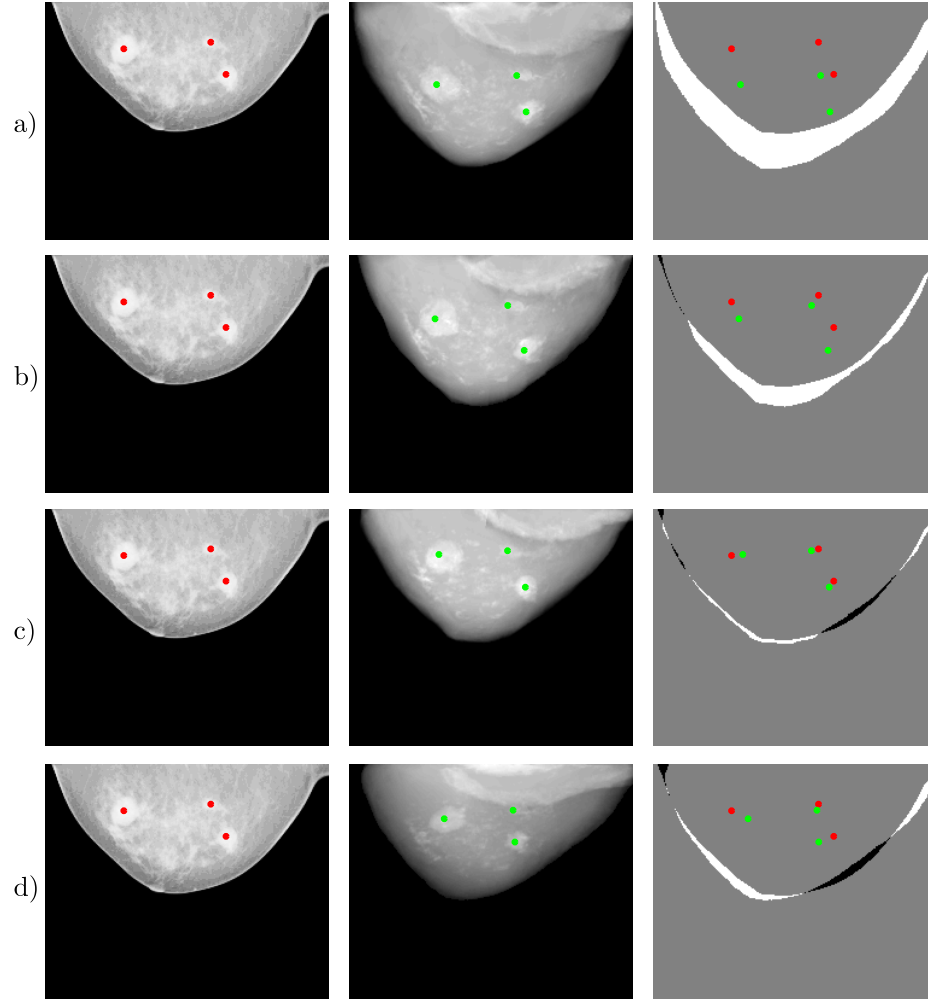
Comparison of X-ray mammogram (left) and projection of deformed MRI volume (middle) for one patient with three marked lesions. The right images express the overlap of both images by subtracting the binary area of X-ray mammogram and the projection of deformed MRI volume. a) Isotropic model without unloaded state estimation and optimization, b) isotropic model without unloaded state estimation and optimization of cut_z , c) isotropic model with unloaded state estimation and optimization of all six parameters, d) orthotropic model without unloaded state estimation and optimization of all 12 parameters. The red dots depict the lesion annotations in the mammogram, the green dots the lesion annotations in the MRI volume after deformation and projection.
